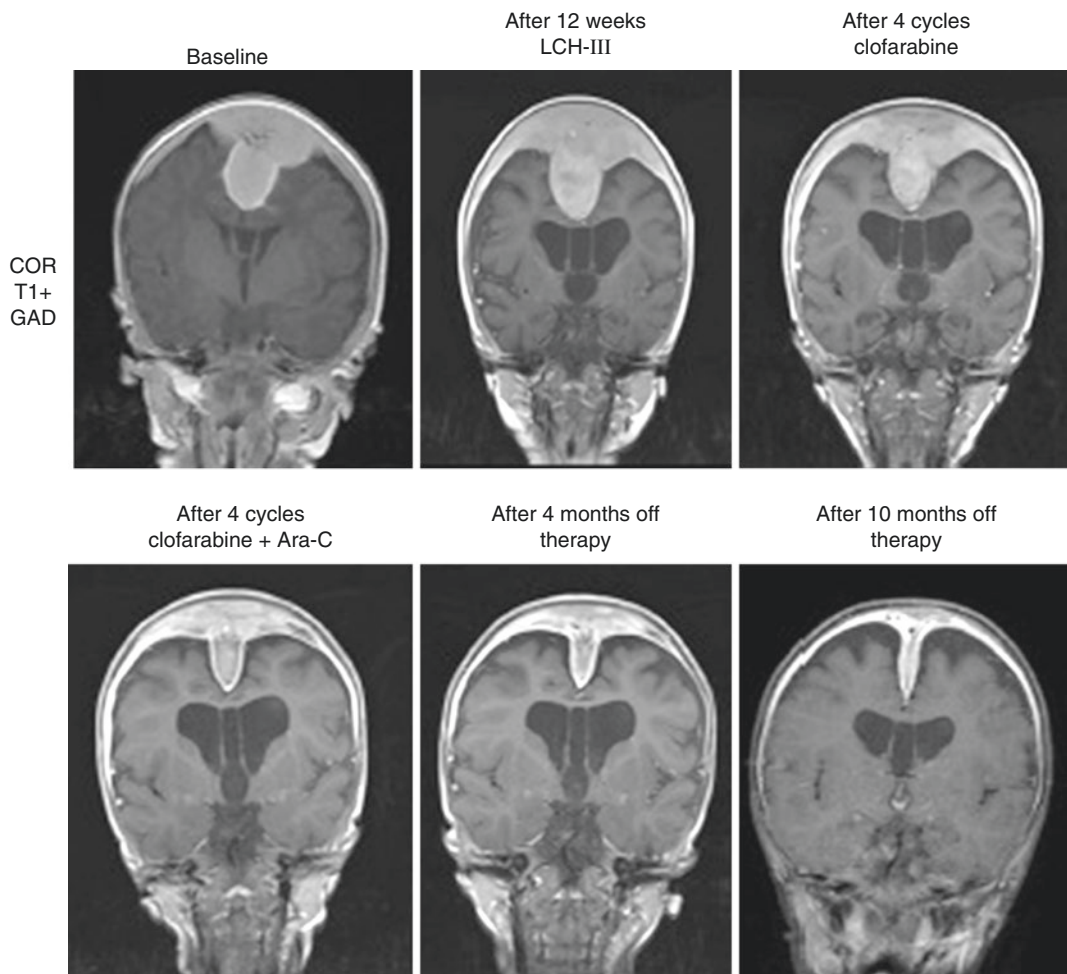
Brain MRI from a child with intracranial JXG: Improvement of the intracranial mass size over the course of treatment with clofarabine-based regimen (Courtesy of Dr. Ronald Anderson, Alberta Children's Hospital, Calgary)
